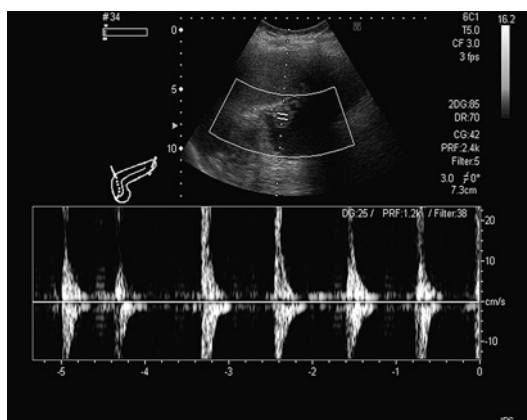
Color Doppler sonogram.
